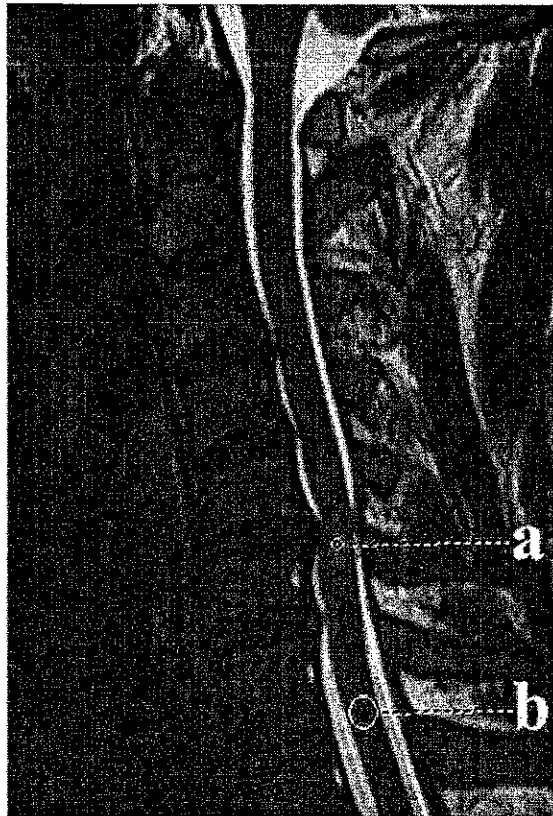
Measurement of SIR on MRI. SIR was defined as the signal intensity of (a and b).
